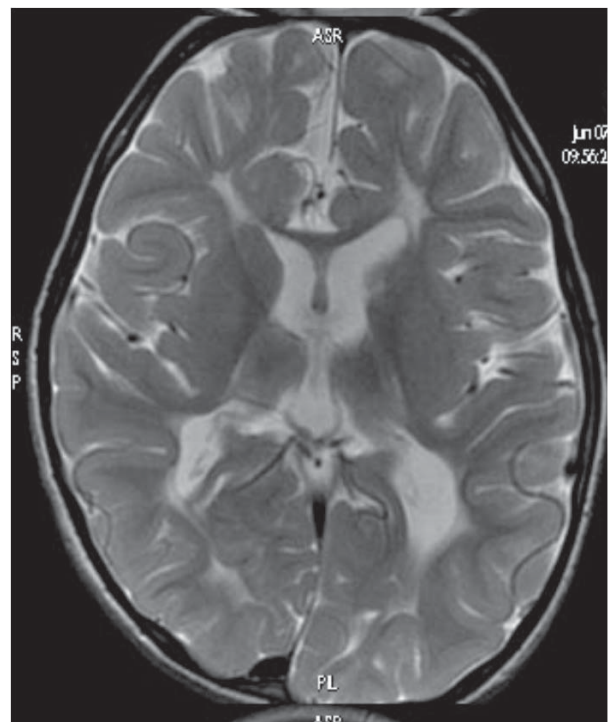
Periventricular leukomalacia hyperintensities in white matter, loss of white matter and ventriculomegaly (T2 MR image).
